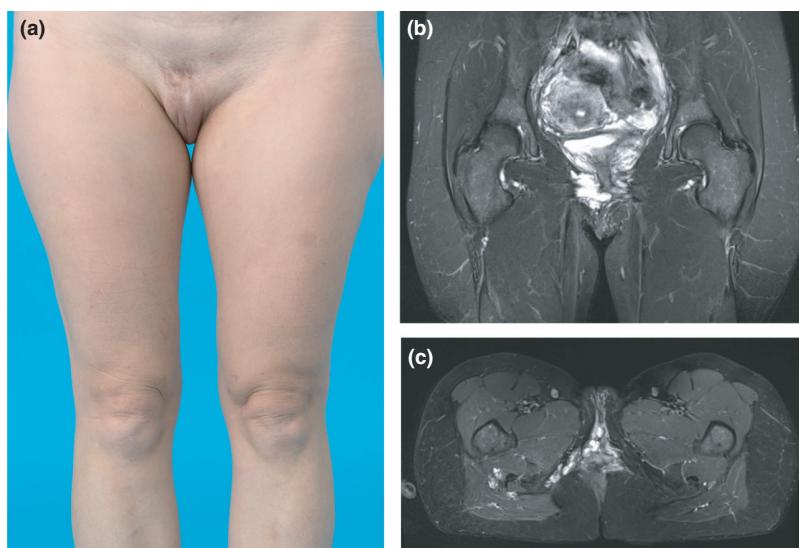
(a–c) Venous malformation: (a) clinical image of the pelvis and legs; (b,c) contrast-enhanced T1-weighted magnetic resonance image in (b) coronal view and (c) axial view of the same area, showing discrete external involvement of the right labia and extensive internal involvement (vagina, cervix, uterus, right ovary).
